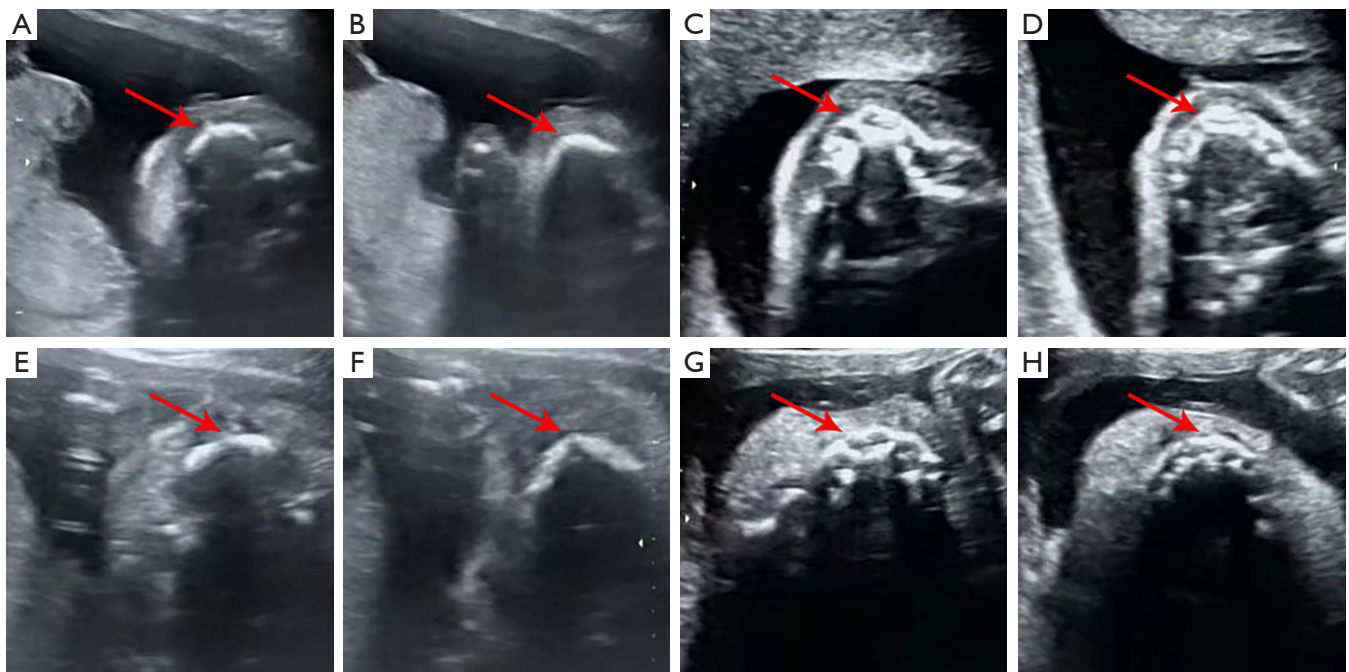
Comparison of intrauterine ultrasound images between the patient and normally observed fetus. At 30 weeks of pregnancy, the alveolar arch thickness was 3.5 mm in the patient and 7.6 mm in the normally observed fetus. (A,B) Ultrasonography of the alveolar bone of the affected fetus at 23 weeks of gestation, the red arrow in (A) is the upper the alveolar bone, the red arrow in (B) is the inferior alveolar arch. (C,D) Ultrasonography of the alveolar bone of the normally observed echogram of the alveolar bone of fetus at 23 weeks' pregnancies, the red arrow in (C) is the upper the alveolar bone, the red arrow in (D) is the inferior alveolar arch. (E,F) Ultrasonography of the alveolar bone of the affected fetus at 30 weeks of gestation, the red arrow in (E) is the upper the alveolar bone, the red arrow in (F) is the inferior alveolar arch. (G,H) Ultrasonography of the alveolar bone of the normally observed echogram of the alveolar bone of fetus at 30 weeks' pregnancies, the red arrow in (G) is the upper the alveolar bone, the red arrow in (H) is the inferior alveolar arch.
